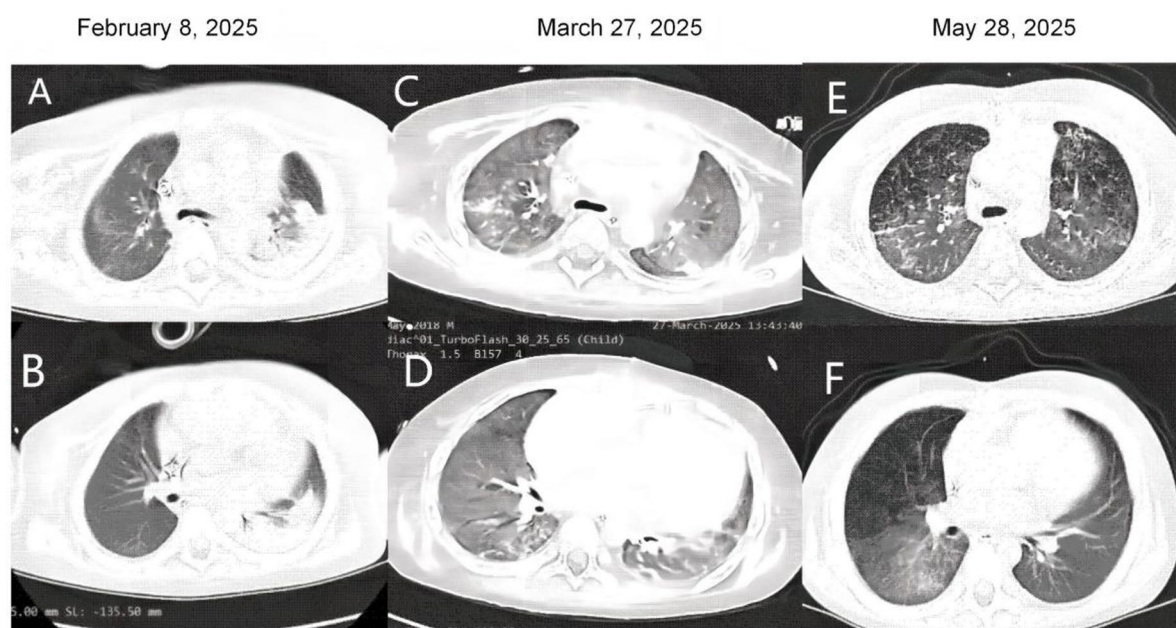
A relatively normal thoracic computed tomography (CT) scan at the initiation of tacrolimus treatment in February 2025 A, B. In March 2025, during TI-ILI, the CT revealed multiple infiltrations, extensive pulmonary ground-glass opacities, and interstitial lung disease C, D. Discontinuation of Tacrolimus and oral prednisolone resulted in complete recovery, as evidenced by the resolution of infiltrations on chest CT prior to discharge in May 2025 E, F. Abbreviations: CT, computed tomography; TI-ILI, tacrolimus-induced interstitial lung injury
